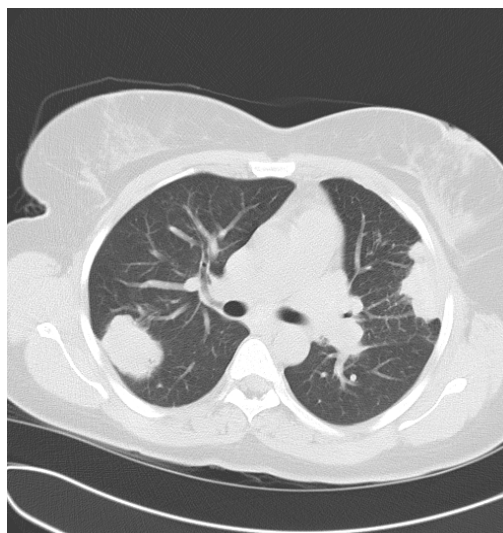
CT scan of the chest demonstrating circumscribed nodules
